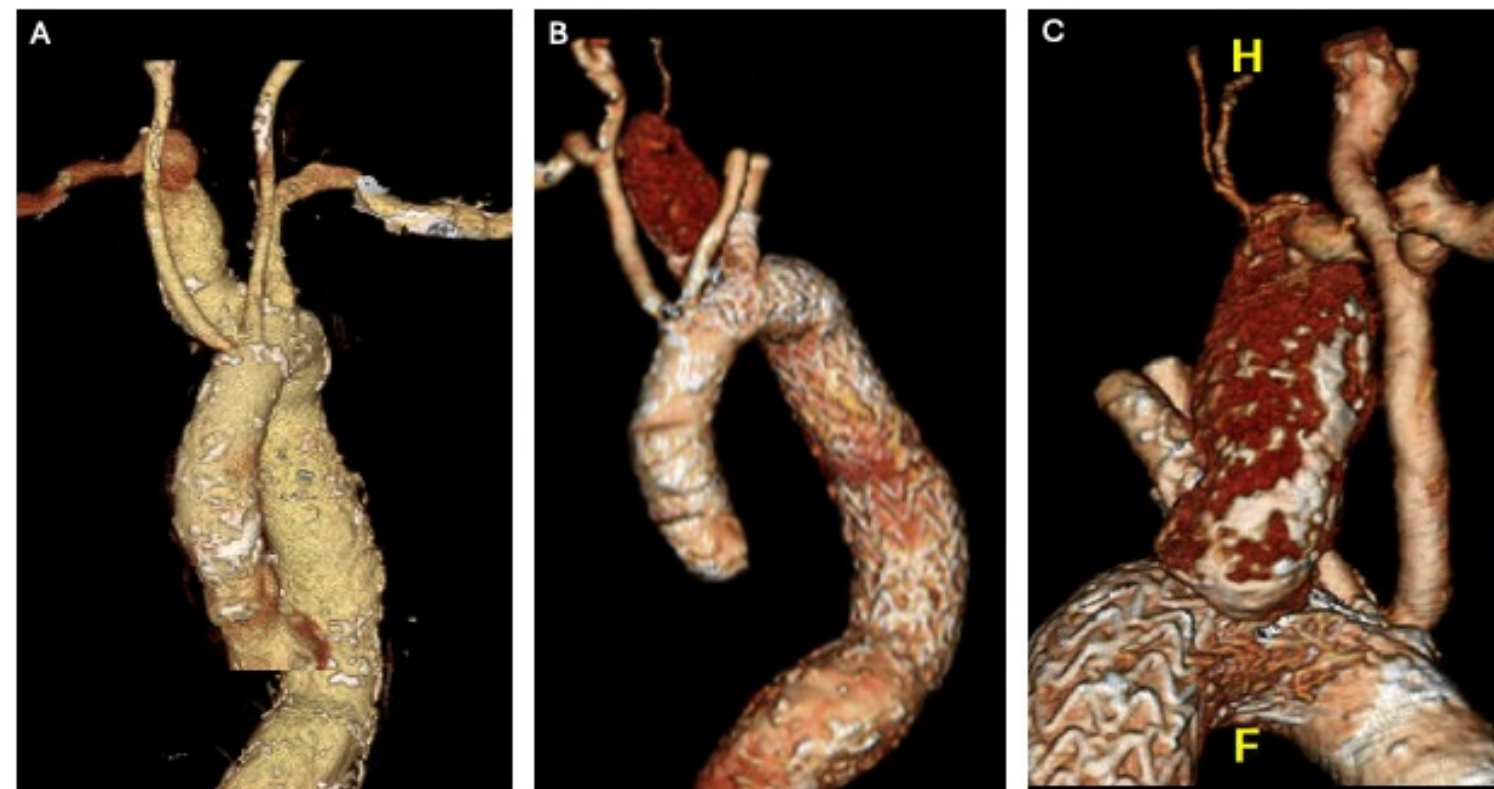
Computed tomography (CT) pre and post procedure. CT angiogram reconstructions pre (A) and post (B,C) treatment. (A) Aberrant right subclavian artery extending posterior to the trachea and esophagus with fusiform bilobed aneurysm in the intrathoracic segment measuring up to 3.7 cm. (B) A stent remains in the arch and throughout the descending segment in stable position and appears widely patent. The stent covers the origin of the aberrant right subclavian artery which has been reimplanted. (C) Image demonstrating the transection of the aberrant right subclavian artery and reanastomosis to the right common carotid artery.
